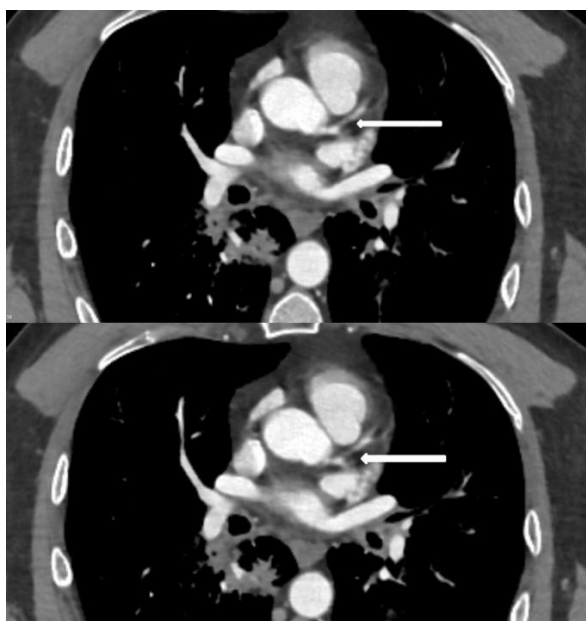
Thoracic CT Angiogram Image Suggestive of Coronary Occlusion.
